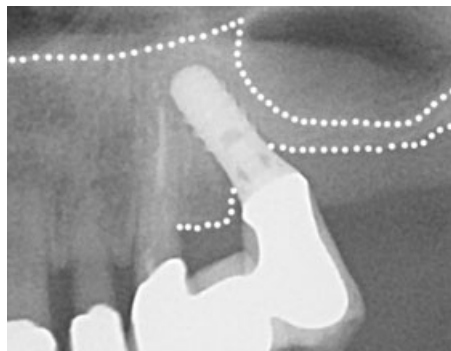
Radiograph showing a tilted implant placed in the position of 25 to avoid entering the sinus cavity. After remodeling, the bone level on the distal aspect of the implant is more apical than at the time of implant placement. This may lead to increased probing pockets depths around tilted implants. (The dotted lines represent the outlines of the residual bone.)
